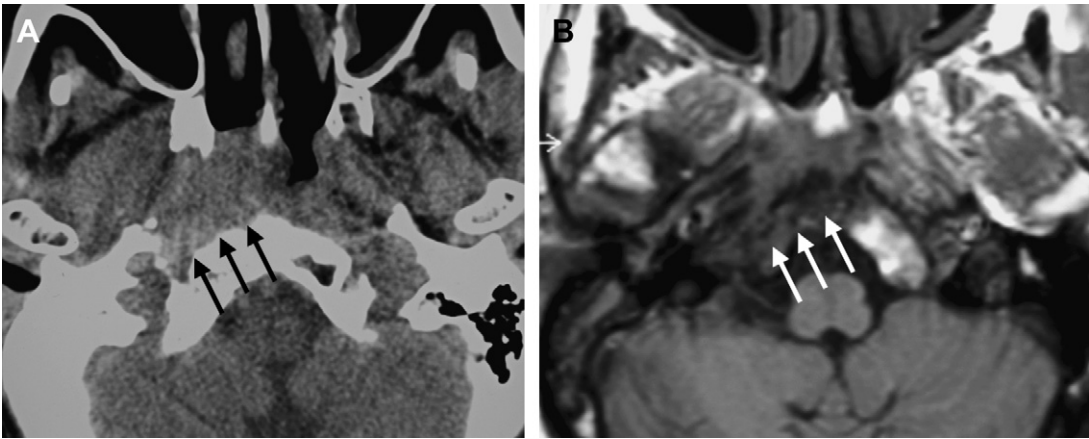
Plain axial CT scan (A) and axial T1-weighted MR image (B) show a mass lesion in the posterolateral wall of the nasopharynx obliterating the fossa of Rosenmüller, effacing the parapharyngeal fat, and growing posteriorly into the jugular foramen. Note the sclerosis and slight irregularity of the cortical margin of the right lateral aspect of the clivus on the CT image (*black arrows*) corresponding to replacement of the fatty marrow, which is best appreciated on MR imaging (*white arrows*).
